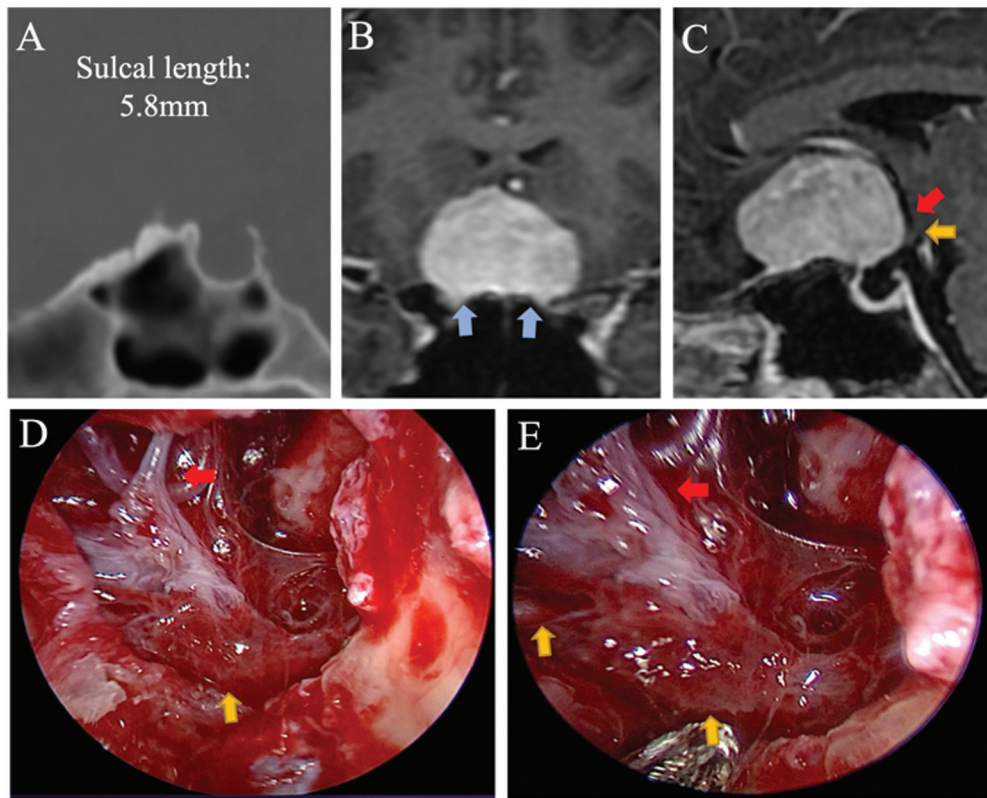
Case demonstration of type C chiasmatic sulcus meningioma. (A) CT scan sagittal view of the sellar area showing the sulcal length. (B) MRI with contrast coronal view showing tumor extension to the left optic canal (blue arrow). (C) Sagittal MRI with contrast showing the displacement and the separation of neurovascular structure posteriorly, optic chiasm (yellow arrow) and superiorly A1/A2 complex (red arrow). (D) Intraoperative picture of the arachnoid layer (medial lamina terminalis membrane) after removing the tumor as it was resting over it and protecting the optic chiasm. (E) Intraoperative picture after removing the tumor showing the separation between the optic chiasm and A1/A2 complex.
